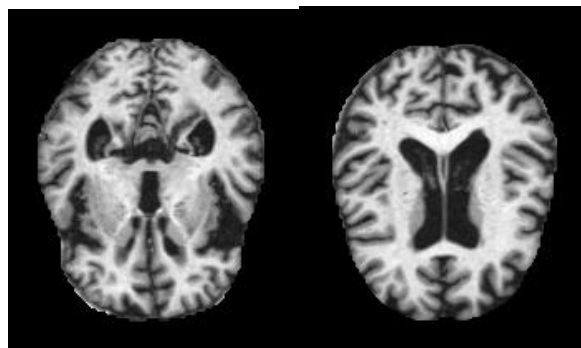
MRI Scans (Lower Brain Left, Upper Brain Right)
